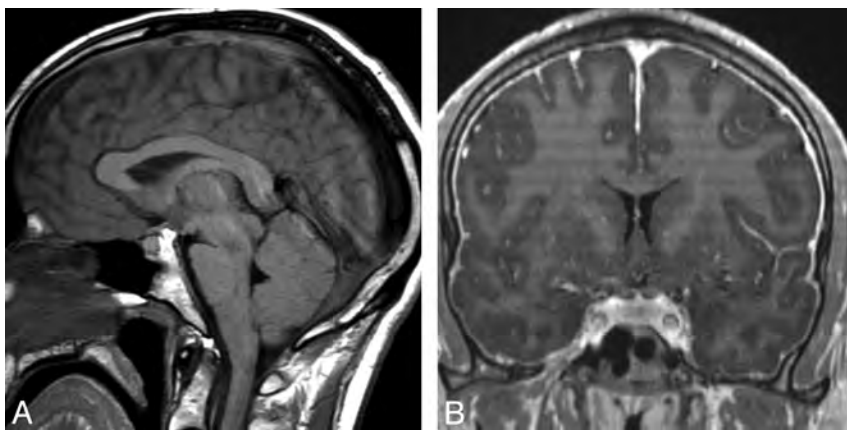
A, Sagittal T1-weighted MR image shows descent (“sagging” or “sinking”) of brain, enlargement of the pituitary gland, and obliteration of the cisterns. B, Coronal postcontrast T1-weighted MR image of the same patient shows diffuse pachymeningeal enhancement.
